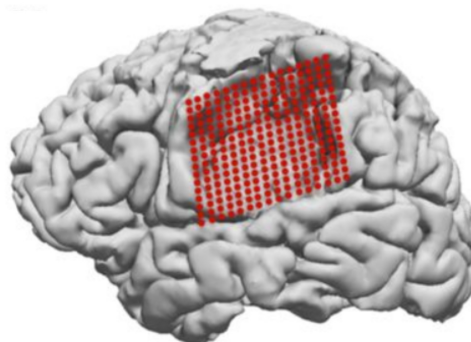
MRI showing ECoG electrodes in grid array (red). This configuration allows to capture precise brain activity at appropriate physical locations [1].
